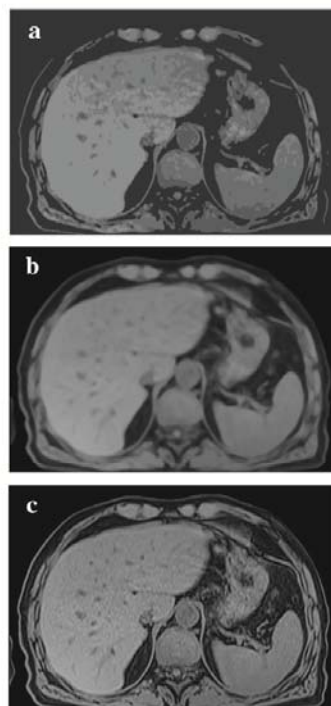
An example of a CT medical image focusing on the liver; presented are a source image (left – a), a filtered image (middle – b), and a fully pre-processed image (right – c).
